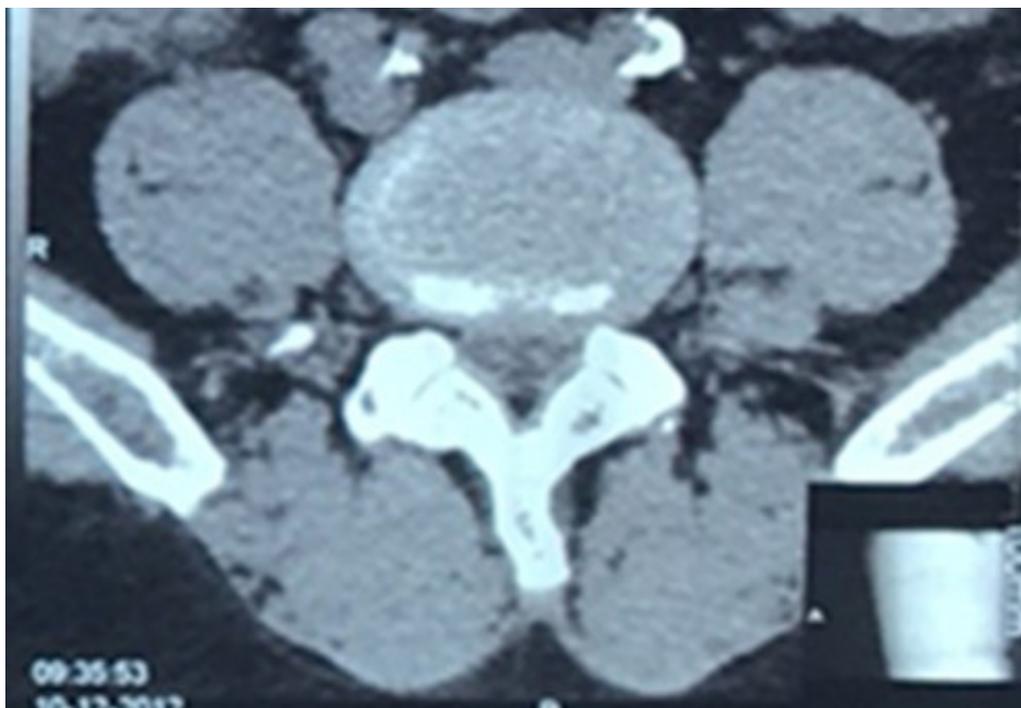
CT shows lumbar disc herniation and stenosis at L4-5 level.
